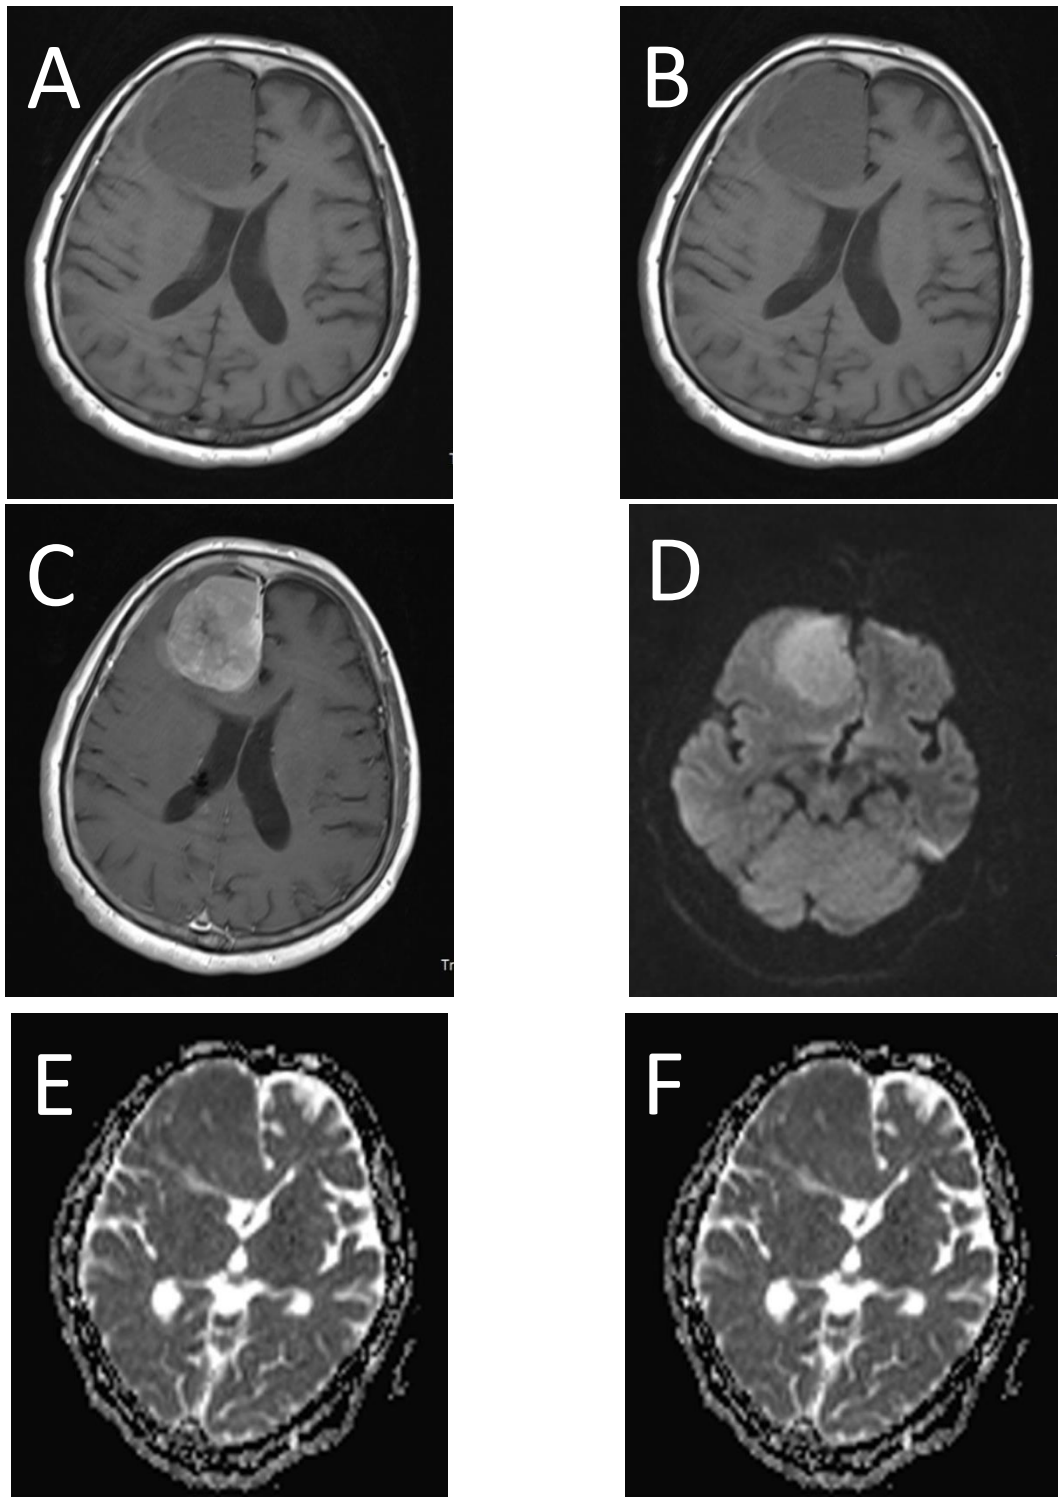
A 70 years old female patient with typical meningioma in the right frontal region. MRI shows isointense lesion in both T1-weighted (A) and T2-weighted images (B). Post-contrast axial T1W (C) shows relatively homogenous enhancement. Diffusion-weighted imaging (DWI) (D) shows diffusion restriction. The apparent diffusion coefficient (ADC) (E) shows hypointense signal. Sagittal T1W image shows avid post-contrast enhancement (F)
